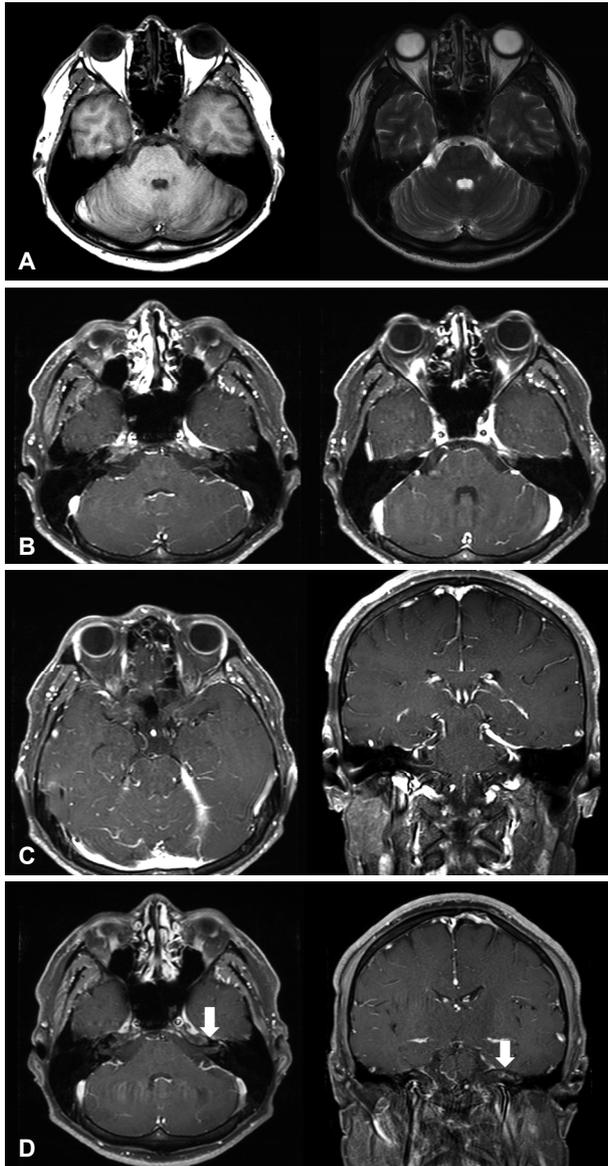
Brain MRI of patient. T1- and T2-weighted images revealed mild bulging soft tissues in the left cavernous sinus (A). Enhanced T1-weighted image shows a thickening and enhancement of the left cavernous sinus and superior orbital fissure (B), and of the left tentorium (C). Three weeks later, abnormal enhancement is visible in the facial nerve (arrow), suggesting inflammatory facial nerve disease in T1-weighted images (D).
